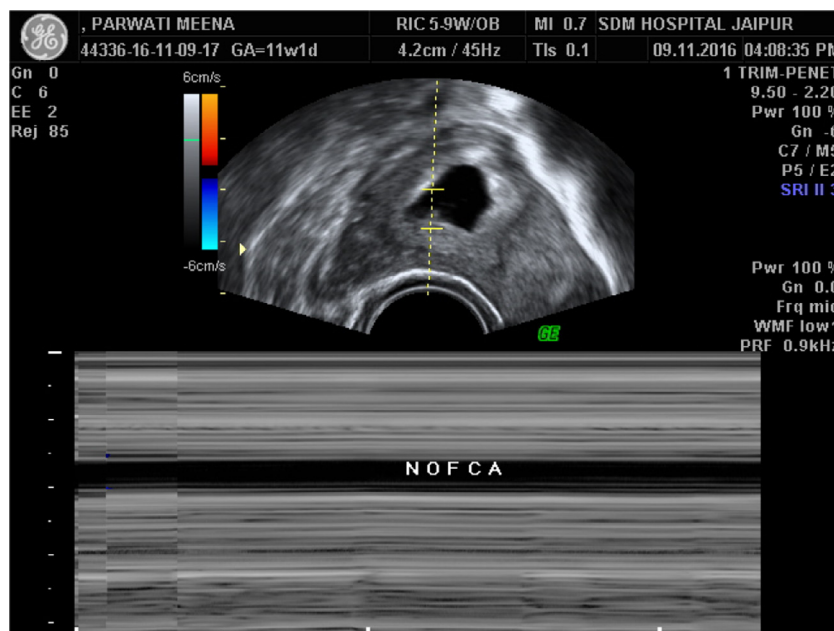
Ultrasonography scan showing absence of foetal cardiac activity.
